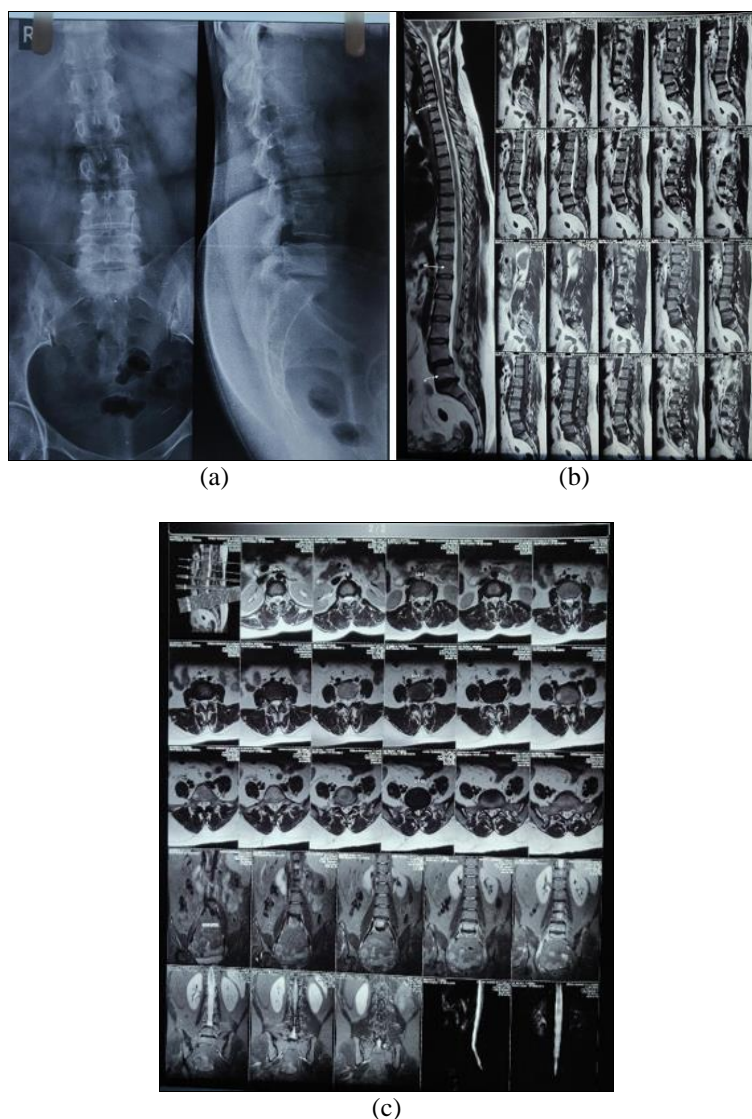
a) preoperative x-ray, b) preoperative MRI – saggital section, c) preoperative MRI – axial section
